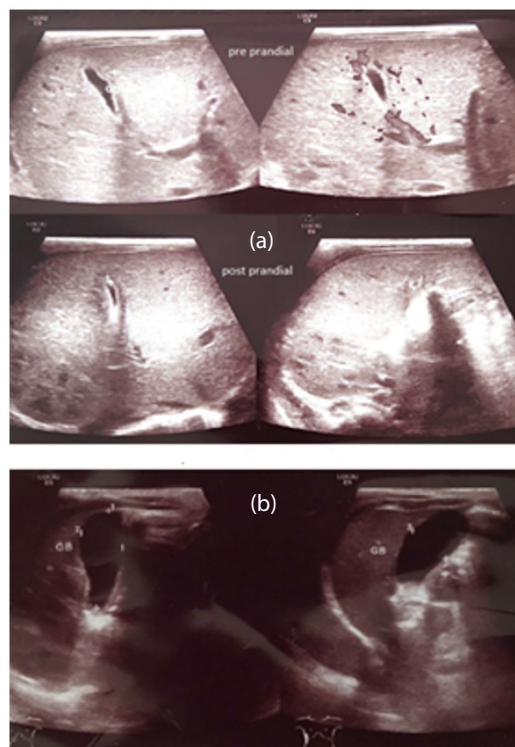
Abdominal ultrasonography of the patient. (a) Before therapy and (b) After therapy
